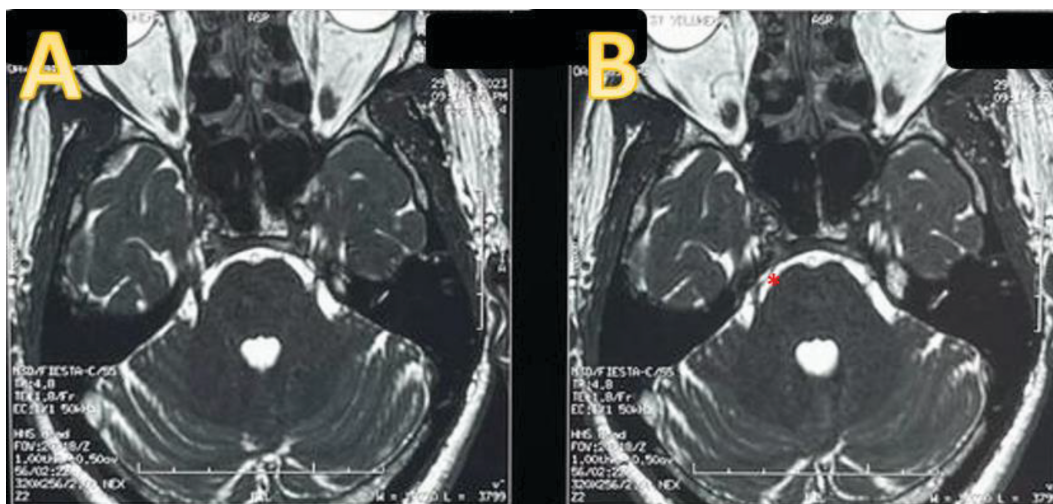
High-resolution MRI utilizing steady-state precession images showing (A) bilateral trigeminal nerves and (B) loop of a superior cerebellar artery (asterisk) crossing trigeminal nerve.
